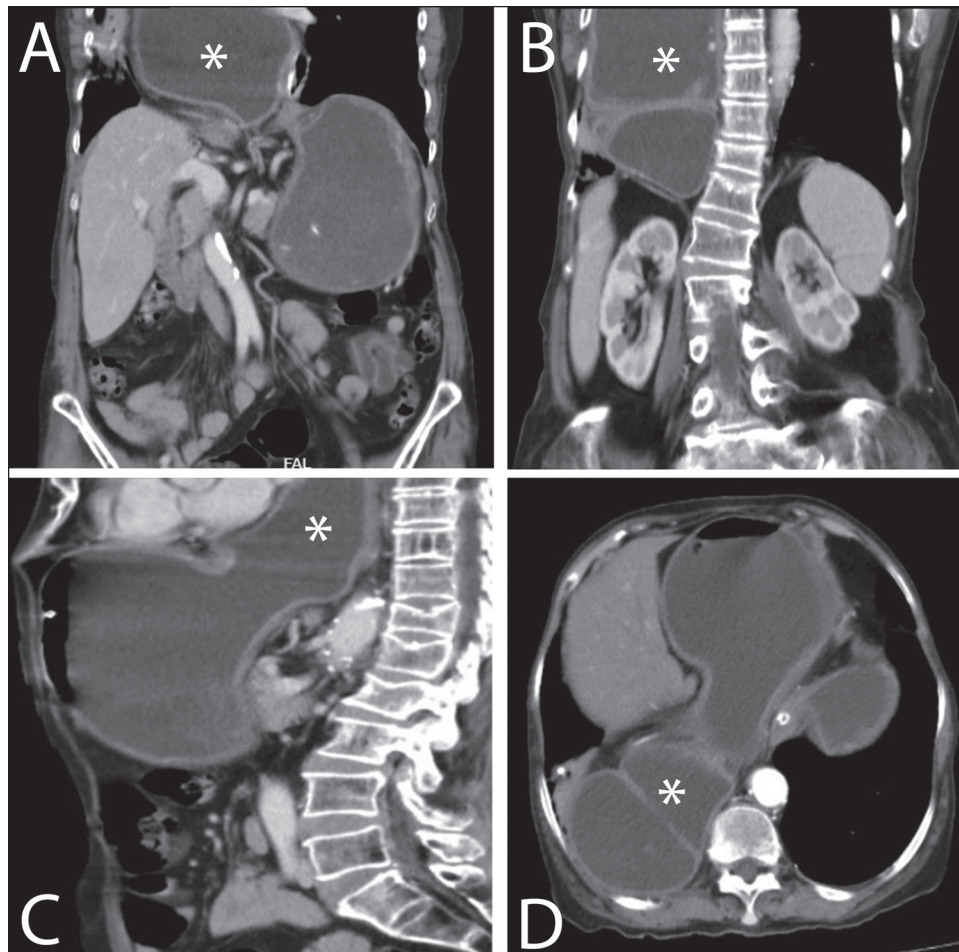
Computed tomography sections in different views showing the duodenum (marked as asterisk) in the right hemithorax. (A and B) Coronal view. (C) Sagittal view. (D) Axial view
